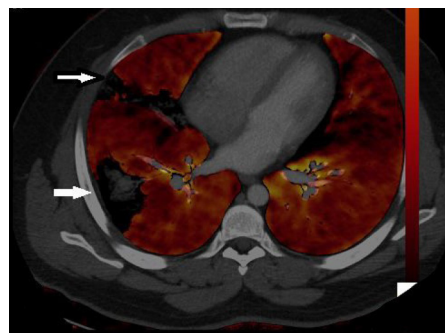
The same patient as in Figure 1. Initial dual-energy computed tomography images. Consolidation-related perfusion deficits are observed (arrows).
